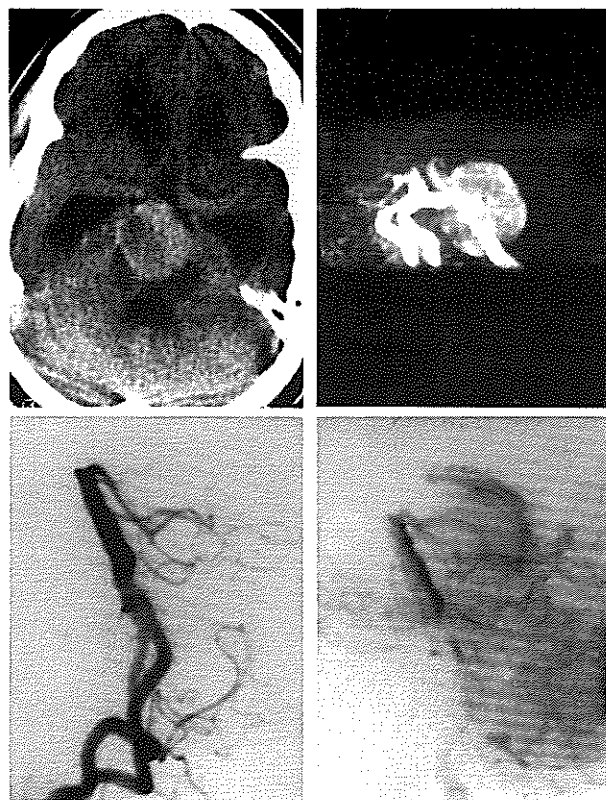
Upper left: Head CT scan without contrast showing a large hyperdense lesion occupying the prepontine cistern causing severe compression of the brain stem and obstructive hydrocephalus. Upper right: 3D time-of-flight MRA showing a 32 mm. spherical area of increased signal at the basilar artery trunk. Lower left: Lateral view of the DSA showing no aneurysmal sac or neck. Lower right: In the venous phase, there was an area of stasis of the dye along the posterior portion of the basilar trunk probably related to the irregularities caused by the thrombus located along the neck area.
